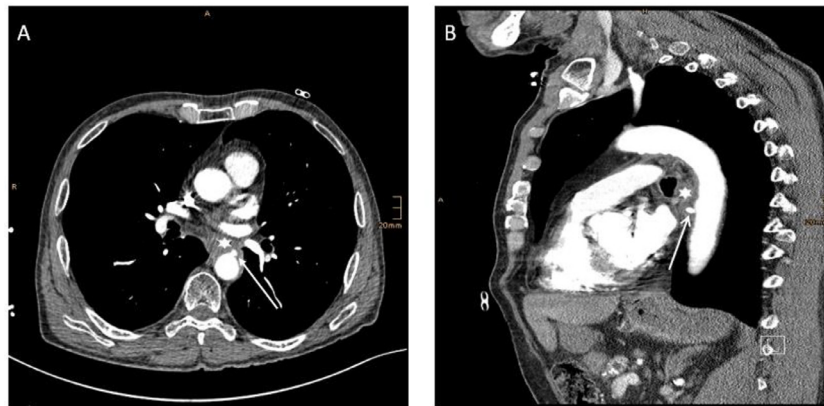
CTA demonstrates the connection between the descending aorta (arrow) and esophagus (asterisk) in form of a pseudoaneurysm in axial (A) and sagittal view (B).
